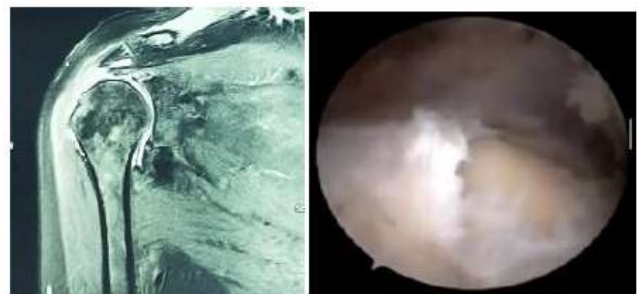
MRI showing complete tear of supraspinatus which was later confirmed on arthroscopy
